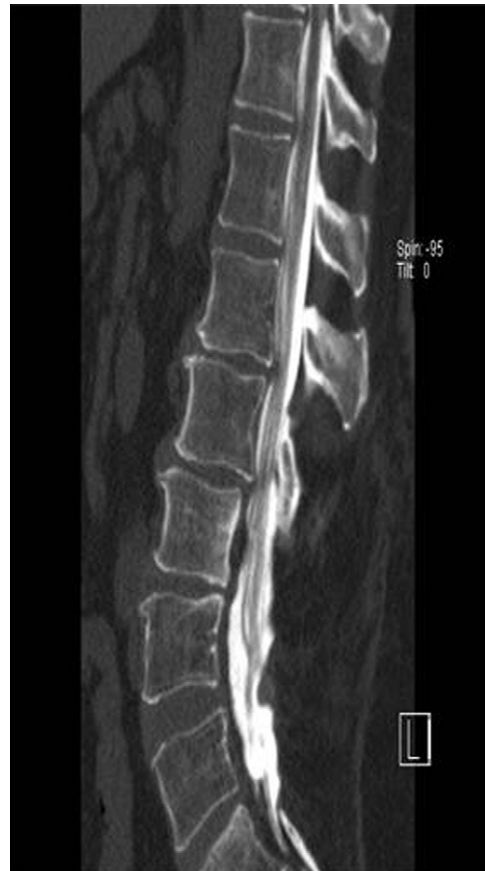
Sagittal CT myelogram showing post-laminectomy spine.
